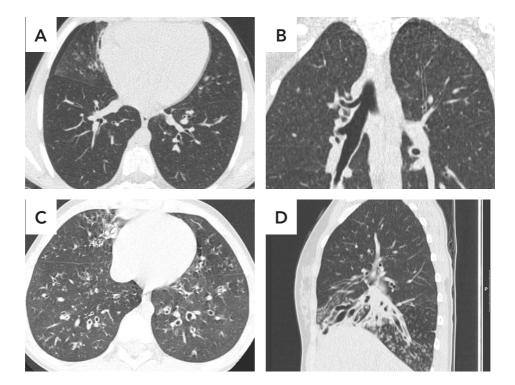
Bronchiectasis. A, This 15-year-old male patient with CVID had bronchiectasis in the middle lobe as demonstrated on this axial CT image. The airways are abutting the mediastinal pleura. B, This 17-year-old female patient with CVID-like disorder had a slight lack of normal tapering in the left upper lobe as demonstrated in this coronal CT image. Note the incidental finding of a tracheal bronchus on the right side. C, This 6-year-old male patient with CVID-like disorder had consolidation in the middle lobe, moderate and mild airway wall thickening in the lower lobes, bronchiectasis in the left lower lobe, and tree-in-bud in the right lower lobe. Note the cardiac pulsation artifact in the lingula and medial left lower lobe. D, This 14-year-old female patient with CVID had severe bronchiectasis (and airway wall thickening) in the middle lobe as demonstrated on a sagittal CT image.
